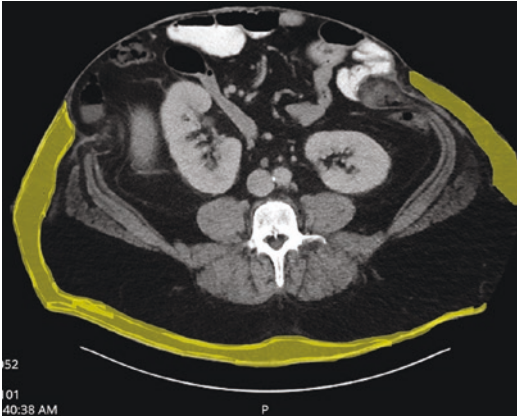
Axial CT scan showing subcutaneous fat highlighted in yellow. Adapted from Levi et al. [56]
